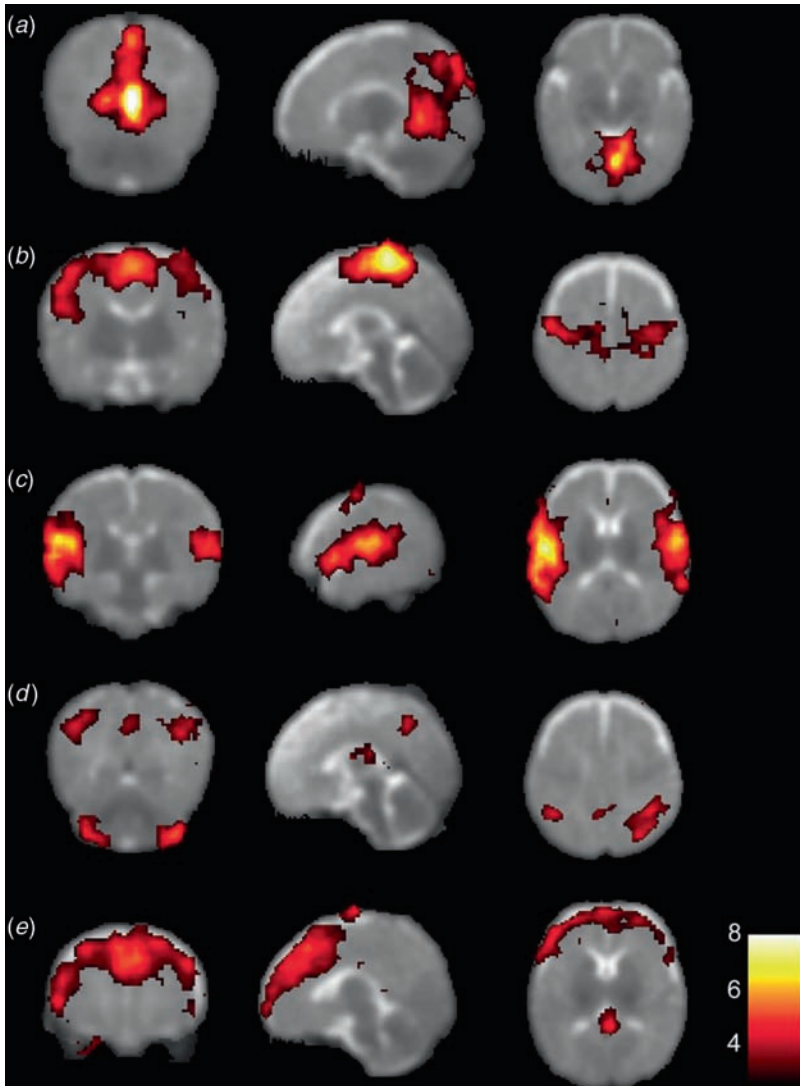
Functional magnetic resonance imaging used to map the resting state activity of the brain in lightly sedated infants around term reveals several unique resting-state networks that encompass (a) the primary visual cortex, (b) the somatosensory and motor areas, (c) primary auditory cortex, (d) posterior lateral and midline parts of the parietal lobe and lateral aspects of cerebellum, and (e) the medial and dorsolateral prefrontal cortex, a network potentially of importance for access to consciousness. (From Fransson *et al.*, 2007.)
